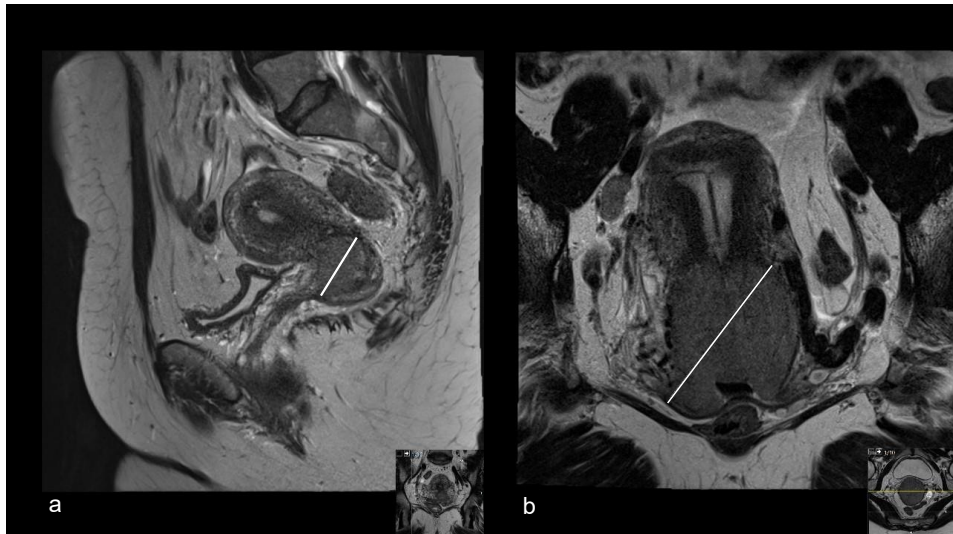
Examples of maximum tumour length measurements (white line) on T2-weighted sagittal image (a) and on coronal oblique (b) image.
